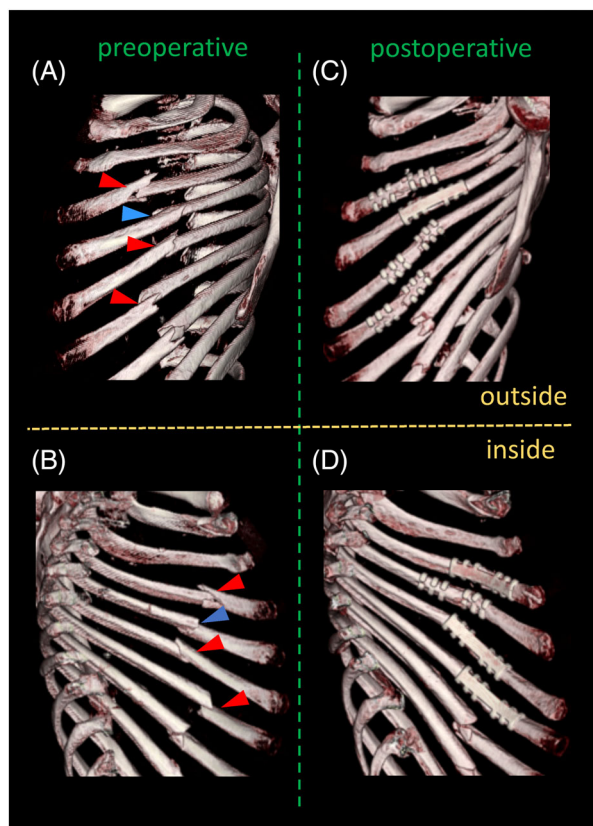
On preoperative three-dimensional computed tomography (A, B), crossed rib edges at the third, fifth and sixth rib fractures were protruding towards the thoracic cavity (red arrowheads). KANI[®] plates were placed from inside the chest wall on these fractures. KANI[®] claws were bent sufficiently (C), and the KANI[®] plates covered the crossed rib edges facing inside the chest wall (D). On the fourth rib fracture (A, B, blue arrowhead) with no significant protruding rib edges, the KANI[®] plate was placed from outside the chest wall (C, D)
